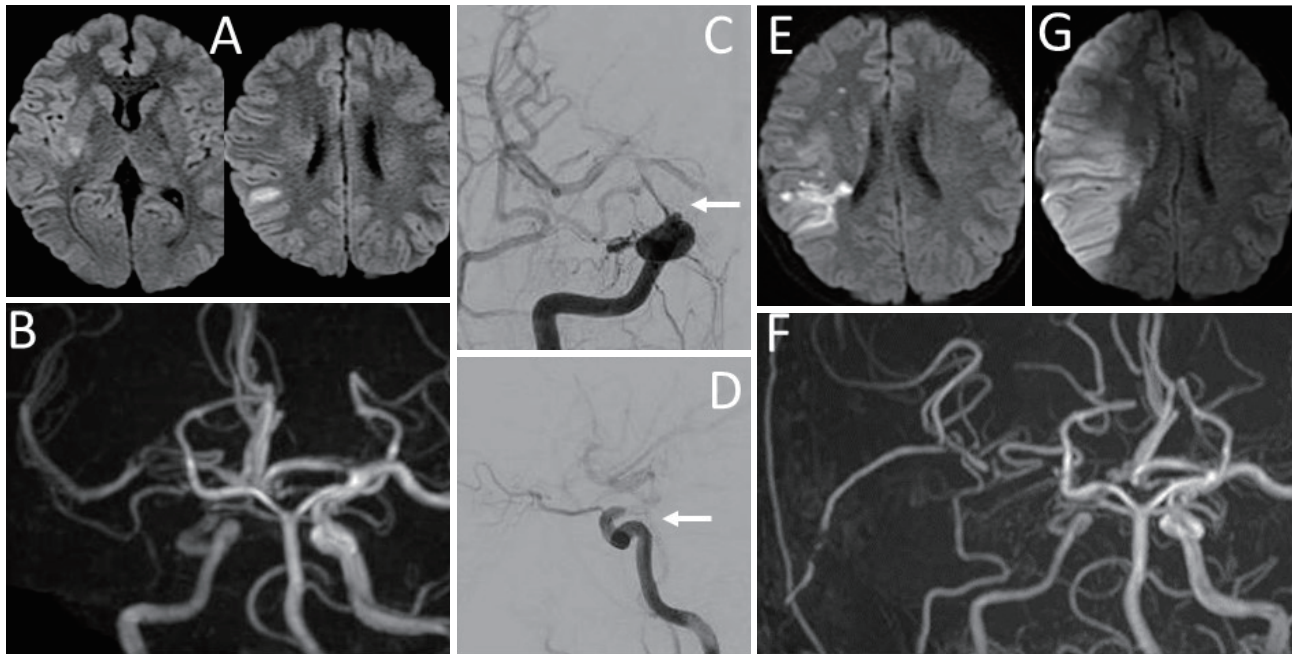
Case 11. A 13-year-old boy presented with a headache and left hemiparesis. A: DWIs on admission showing small hyperintense lesions in the right cerebral hemisphere. B: MRA on admission demonstrating stenosis of the right supraclinoid ICA and M1. C, D: AP (C) and lateral (D) views of the right carotid angiogram on the same day showing tapering stenosis at the right C2 portion (arrow) just distal to the ophthalmic artery. Stenoses and wall irregularities were found in the right M1 and A1. E: DWI 5 days after the onset showing enlargement of the infarction. MRA at the same time showed some aggravation of the stenosis due to the dissection. F, G: MRA (F) and DWI (G) on the next day after surgery showing good patency of the bypass and enlarged infarction reflecting the preoperative aggravation of the symptoms, respectively.
